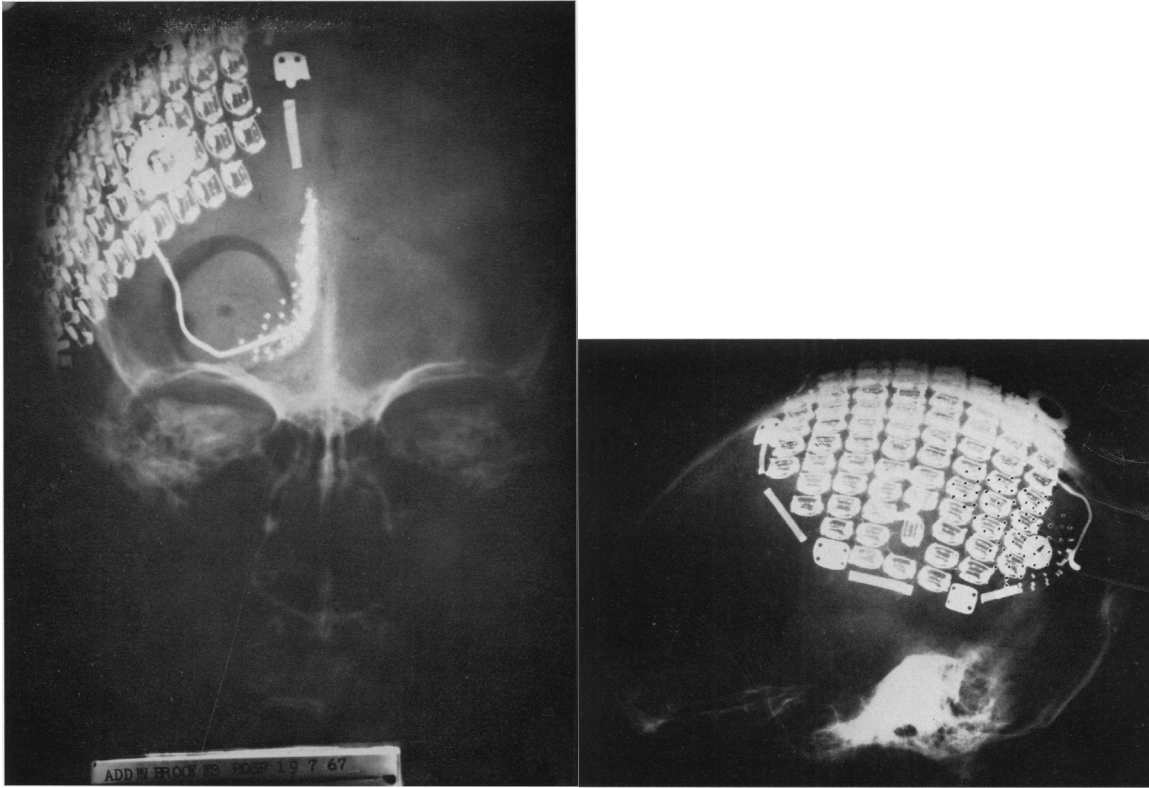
X-ray graphs of cortical visual prosthesis implanted. The 80 stimulation electrodes at the occipital pole, the 80 wireless telemetry coils on the skull surface, and the connecting wires are shown. Adapted from (Brindley and Lewin, 1968)
